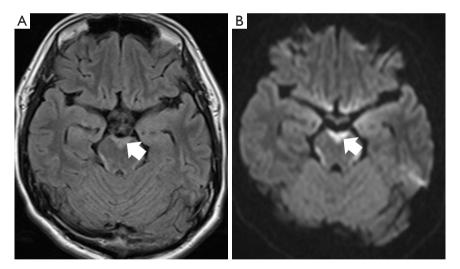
FLAIR (A) and diffusion-weighted image (B) MRI demonstrates the high signal area (arrows) surrounding the brainstem. FLAIR, fluid-attenuated inversion recovery; MRI, magnetic resonance imaging.
